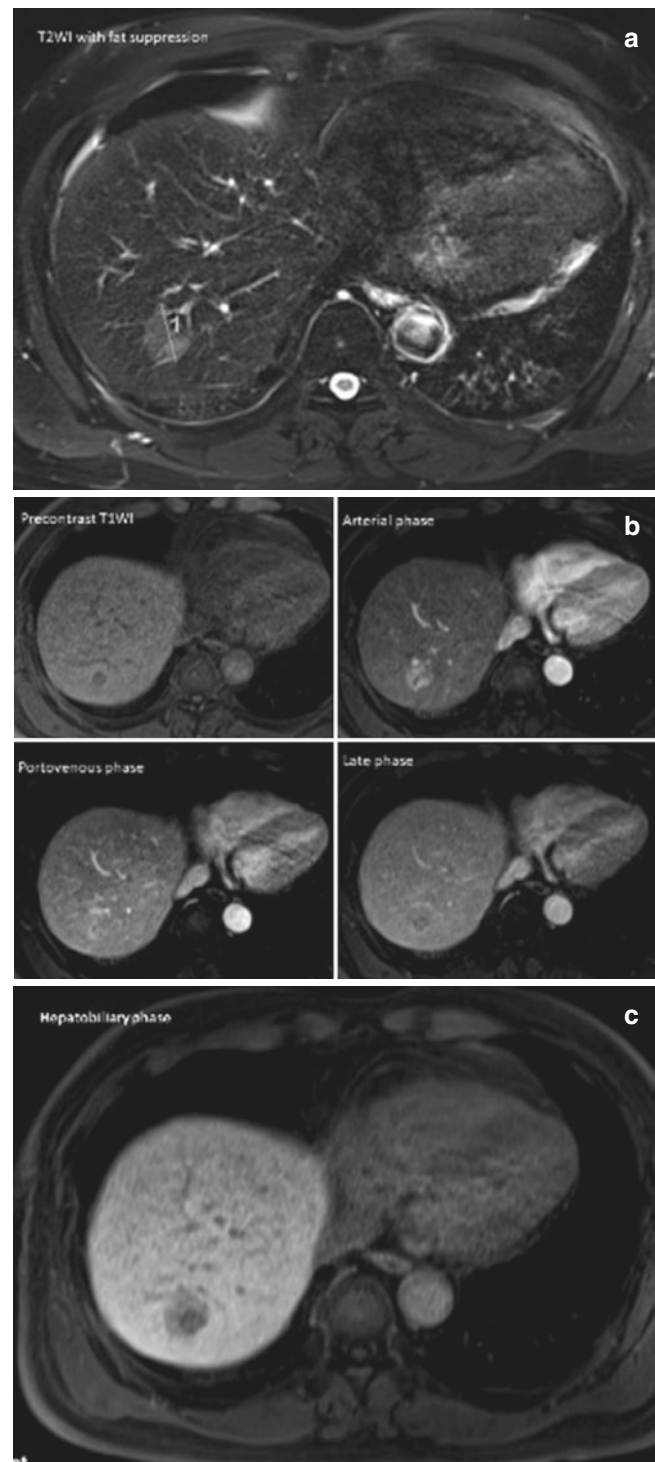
A 78-year-old male with chronic B hepatitis and HCC at S7 of liver underwent Gd-EOB-DTPA-enhanced MR imaging. (a) The tumor is hyperintense on T2WI. (b) The tumor appears isointense with focal hypointense on pre-enhanced T1W imaging, it is heterogenous and hypervascular in arterial phase, and contrast washout on late phase images. (c) The tumor is heterogeneously hypointense on hepatobiliary phase image
